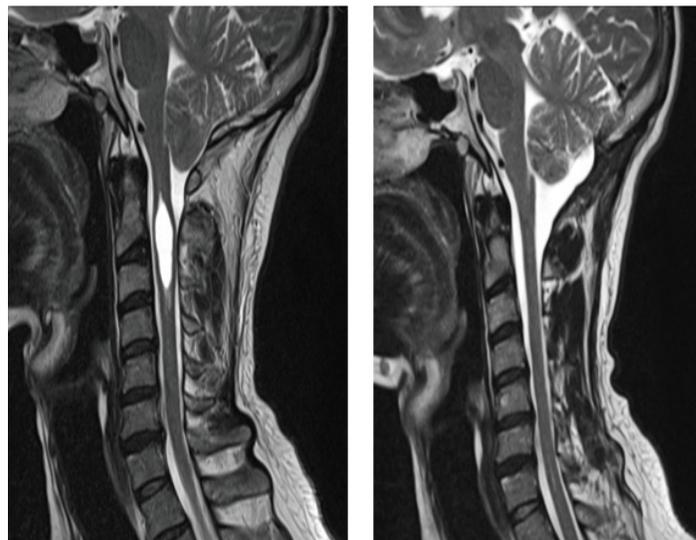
Head MRI scan obtained prior to operative intervention showed the cerebellar tonsil herniated into the superior edge of the posterior arch of the atlas, with associated syringomyelia. Postoperative MRI suggested that cerebellar tonsil was back to normal anatomical position, and resolution of the syringomyelia.
